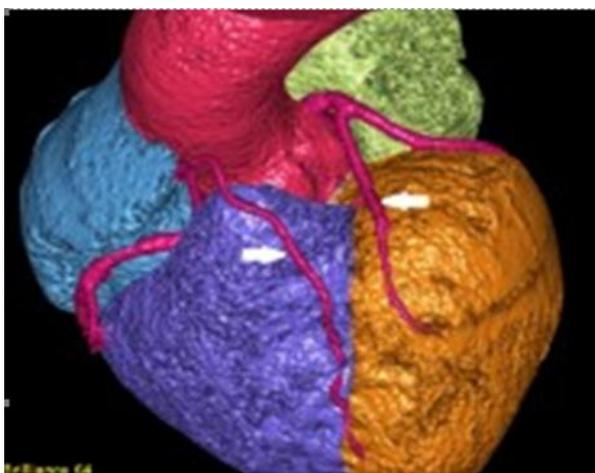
Multislice computed tomography (MSCT) of coronary arteries.
